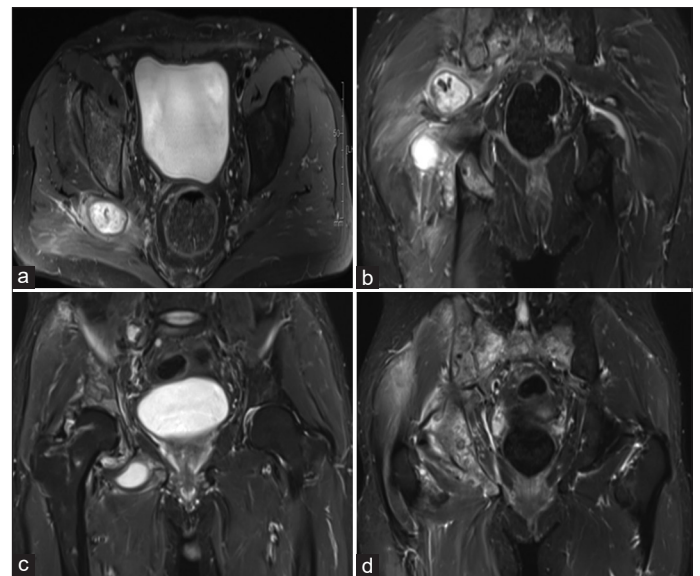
(a-d) Magnetic resonance imaging images of hips and joints showed heterogeneous alteration in sacrum and the right pelvic bone. There was also periosteal collection, cortical, and marrow erosions with inflammatory soft-tissue edema
